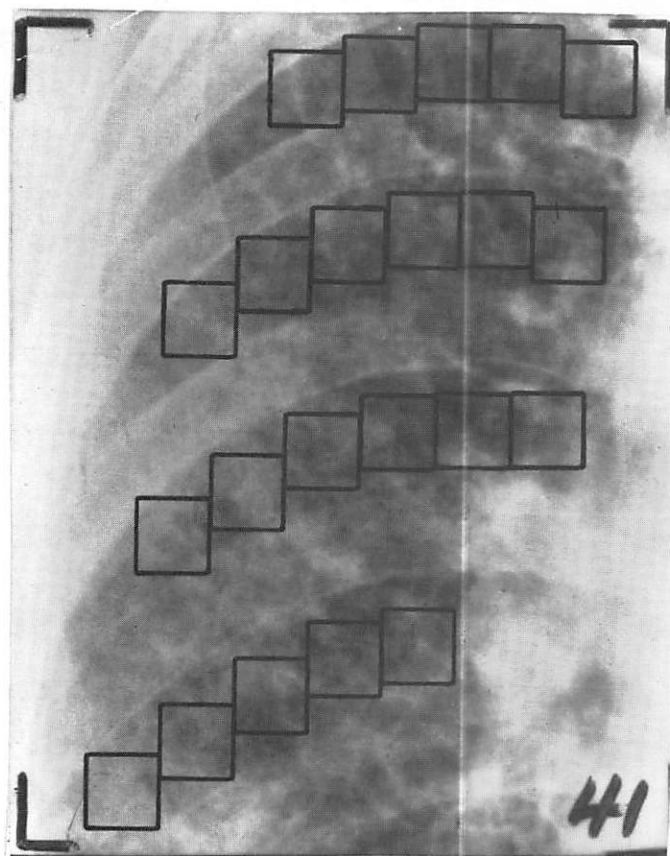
is an example of a normal and abnormal film from the data base. It was decided after consultation with Dr. Turner, that visual diagnosis of simple pneumoconiosis lesions is often arrived at by inspecting the lung regions between the more visually prominent posterior ribs. This seemed logical since it is in these inter-rib spaces that normal vascularity is least obstructed by visual interference from more density radiographic structures. These posterior inter-rib spaces were therefore manually extracted in the following manner. First a computer generated grid was superimposed upon each of the digitized images. This grid allowed visual extraction of from [4 to 10] 100 by 100 pixel squares from each inter-rib space. These squares are delineated for the examples in Figure 3. When extracting squares an effort was made to avoid the most radiographically dense portion of the hilar regions, however no effort was made to avoid the less prominent anterior ribs. Since there were 3 to 4 such inter-rib spaces/film, the complete digital data base consisted of over 1800 such squares and 298 inter-rib spaces.
